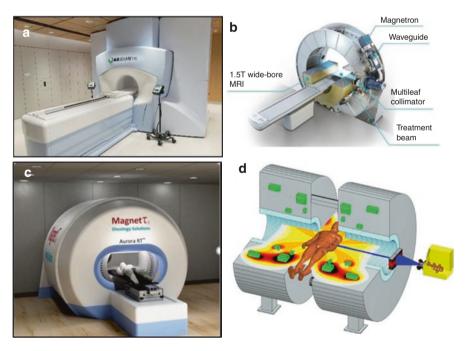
(a) ViewRay MRIdian system, (b) Elekta Unity1.5 T MRI-Linac, (c) Alberta's Aurora RT system, and (d) Australian (Sydney) MRI System in preparation. (Adapted with permission from Das et al., Br J Radiol 2018; 91: 20180505)
